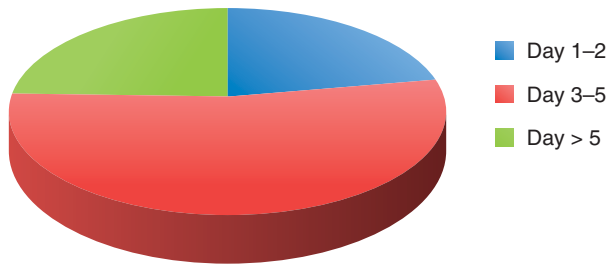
The timing of the first computed tomography in severe acute pancreatitis patients.
